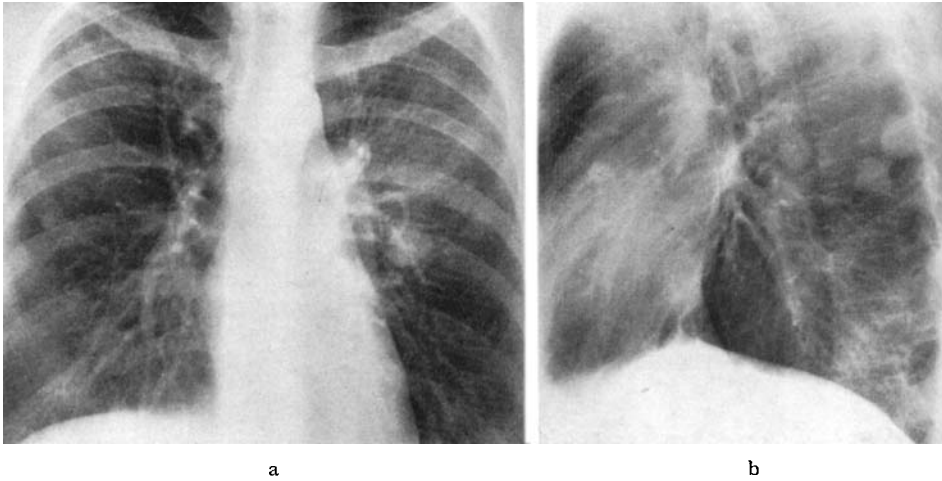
Case 2. Lung roentgenogram (R 1 in fig. 11). Frontal and lateral projections. Multiple metastatic lesions.
